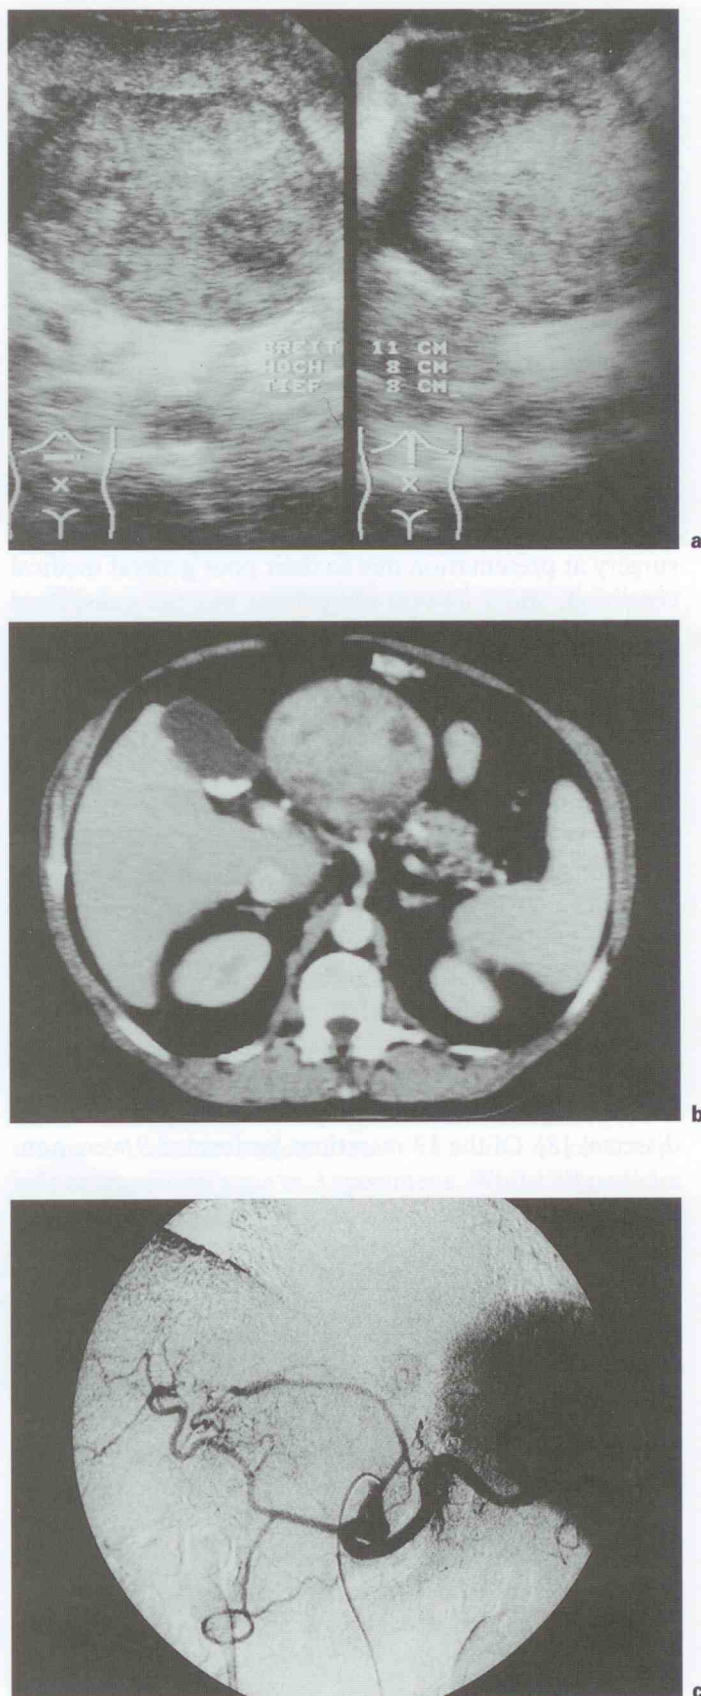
a Ultrasonogram of a 70-year-old patient with a hepatocellular cancer and liver cirrhosis, showing a dependent lesion on the free edge of segment 3. b CT scan of the same patient, showing a spherical lesion with no apparent connection to the liver in a caudal CT cut. c Typical angiographic findings in a pedunculated hepatocellular carcinoma (same patient).
